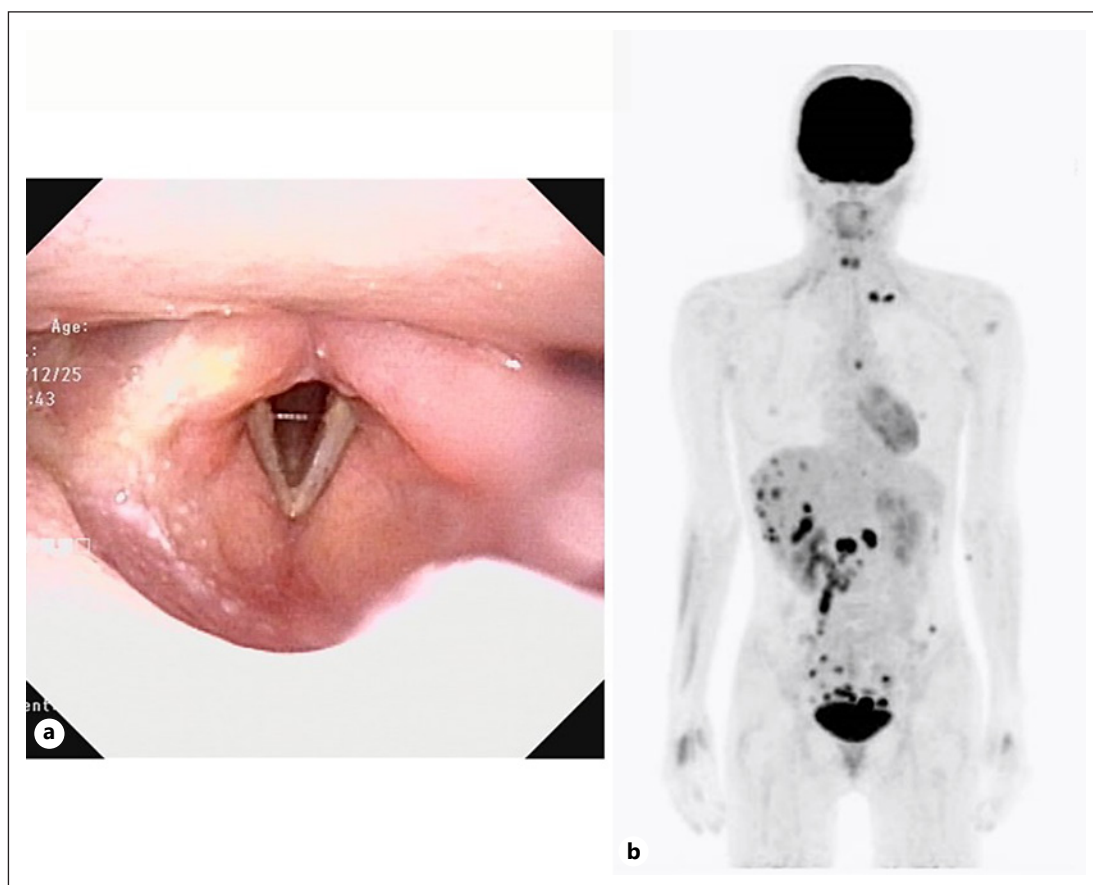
Two months after CRT and 1 month after abdominal surgery. The tumor in the right laryngeal region disappeared, and vocal fold movement was good by laryngeal endoscopy (shown in a). FDG accumulation in the larynx and right neck disappeared in posttreatment FDG-PET. However, FDG accumulation was found in the intra-abdominal lymph nodes, periaortic lymph nodes, liver, and the left venous angle. Multiple intra-abdominal recurrences and Virchow metastases were diagnosed (shown in b).
